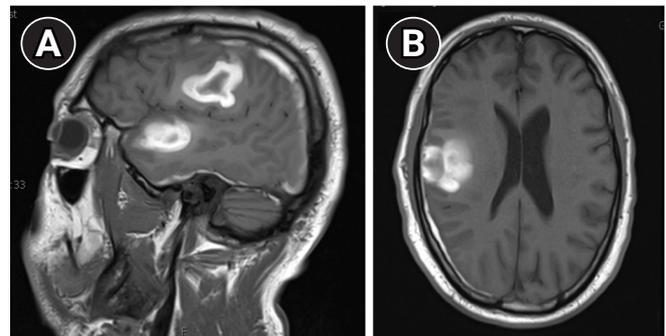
Magnetic resonance imaging without contrast obtained on admission day 14. T1 weighted (A) sagittal image showing the evolution of intraparenchymal hematomas and (B) axial image showing improvement of edema and midline shift.
